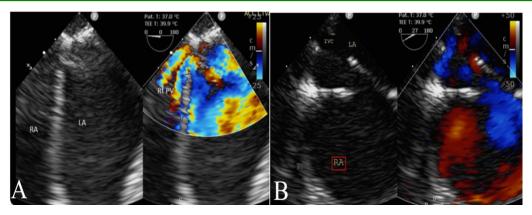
Trans-Esophageal Echocardiography. A Right Pulmonary Veins opening into RA. B dilated RA, with IVC opening to LA.
